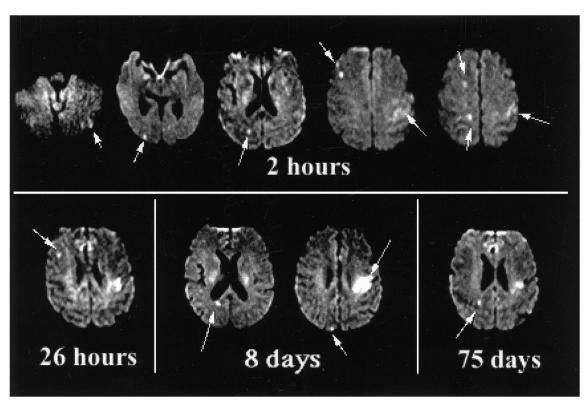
Diffusion-weighted MRI study. Arrows indicate areas of acute ischemic injury.
